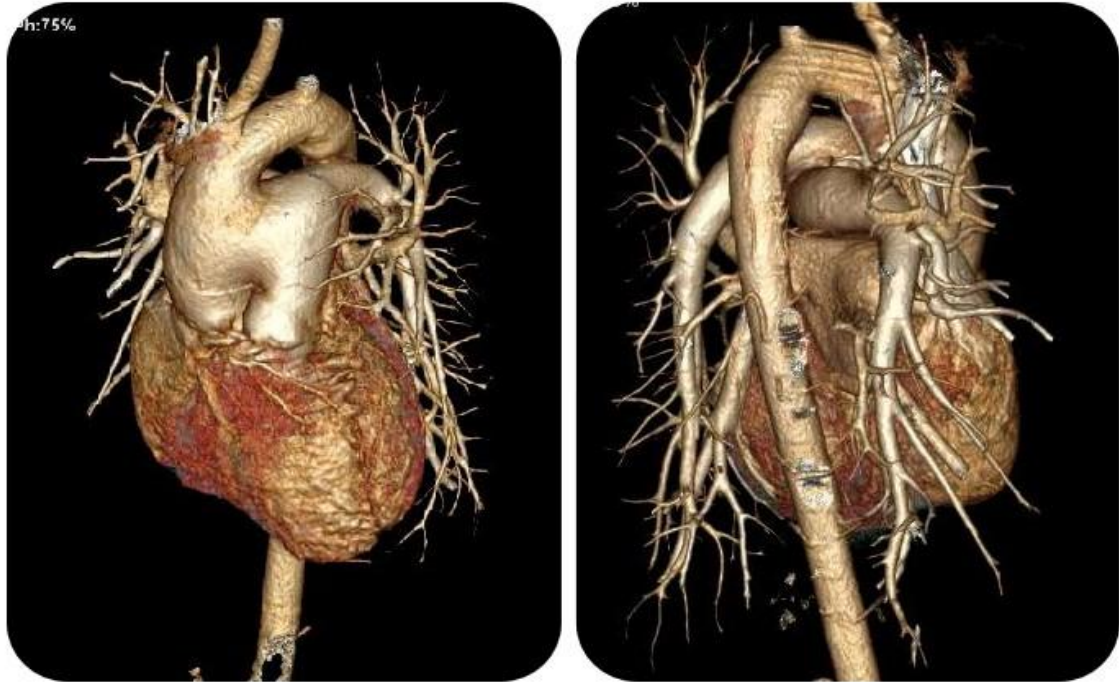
Volume rendered CT images clearly depicting a Aortopulmonary window (Type I defect)
